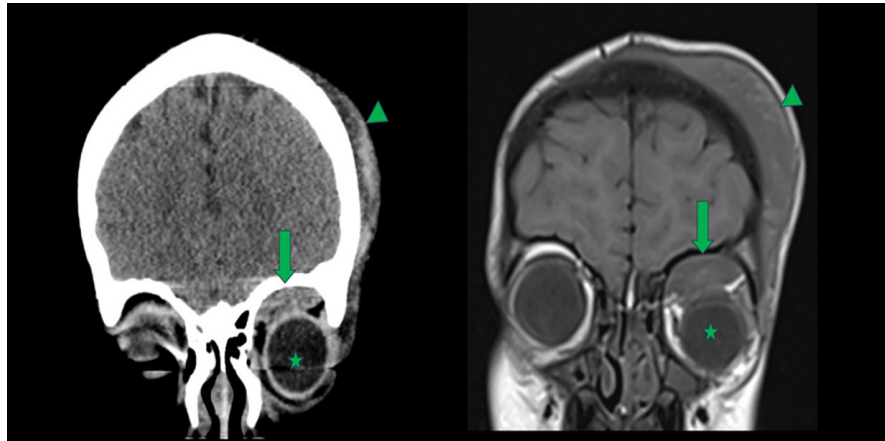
(a) Coronal CT shows a Hyperdense left frontotemporal subgaleal hematoma (arrowheads) and an elliptical hyperdense shaped collection in extraconal space of the superior aspect of the left orbit (arrows) depressing the globe(stars). No fracture of the adjacent bones; (b) A follow-up Coronal T1-weighted MR image shows an interval increase in the size of the subgaleal hematoma and the orbital hematoma, causing a more significant mass effect on the globe(stars), resulting in proptosis. Subtle signal changes within the optic nerve were noted (not shown).
